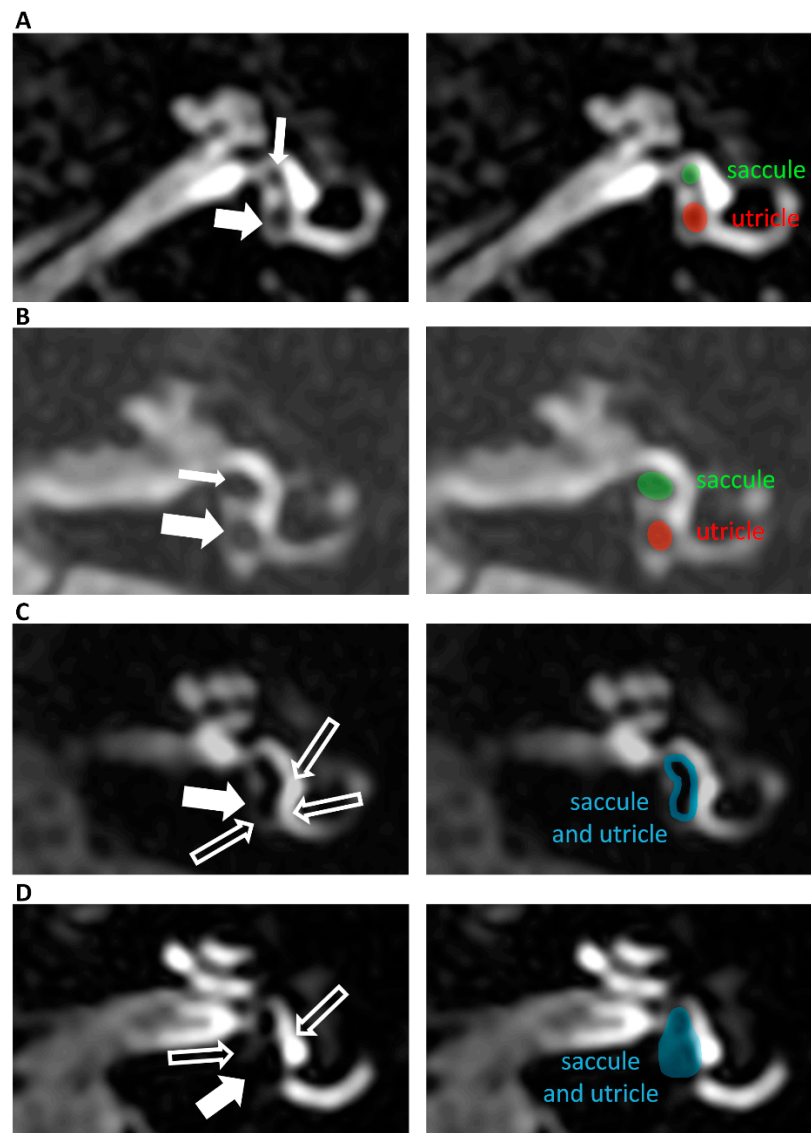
Delayed post-contrast 3D-FLAIR axial images of left ears below the mid-modiolar level (inferior part of the vestibule). The right side images on panel (A–D) show the same images as the left ones in respective panels but in the form of companion scans with some line art applied to define specific anatomical structures for easier identification of observed pathologies. Panel (A) presents a normal vestibule—grade 0 where non-enhancing the saccule (thin arrow) and utricle (thick arrow) are easily visible in the enhancing vestibule. The saccule is smaller than the utricle. Panel (B) presents extra low-grade, that is, grade 1 vestibular endolymphatic hydrophs on Bearnarts scale (but still grade 0 on Barath scale) where the saccule (thin arrow) and utricle (thick arrow) are well separated; however, the saccule is larger than the utricle, and the enhancing vestibule is seen around them. Panel (C) shows grade 2 vestibular endolymphatic hydrophs on Bearnarts scale (grade 1 on Barath scale) where the saccule and utricle are enlarged and confluent (thick arrow); however, thin enhancing boundaries of the vestibule are seen around them (long “empty” arrows). Panel (D) shows grade 3 vestibular endolymphatic hydrophs on the Bearnarts scale (grade 2 on the Barath scale), where significant enlargement of the saccule and utricle is so pronounced that the vestibule is almost totally obliterated (thin “empty” arrow). The saccule and utricle are enlarged and confluent (thick arrow); however, thin enhancing boundaries of the vestibule are seen around them (thin “empty” arrows).
